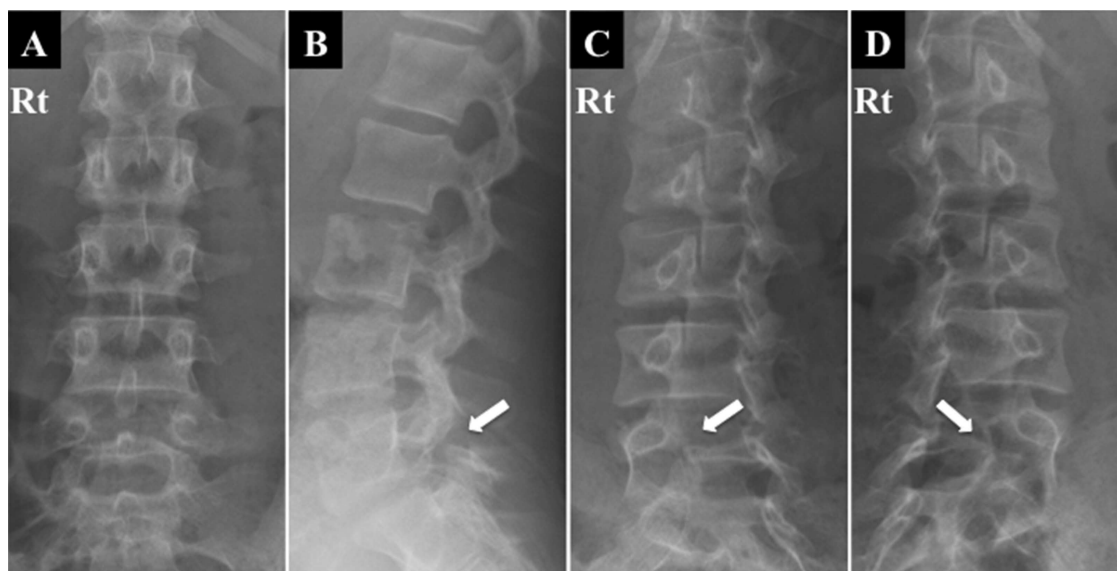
Plain radiographs of the lumbar spine showing spondylolysis at L5 and apparent bone erosion. Anteroposterior view (A), lateromedial view (B), and oblique view (C and D). The arrows shows pars defect.
